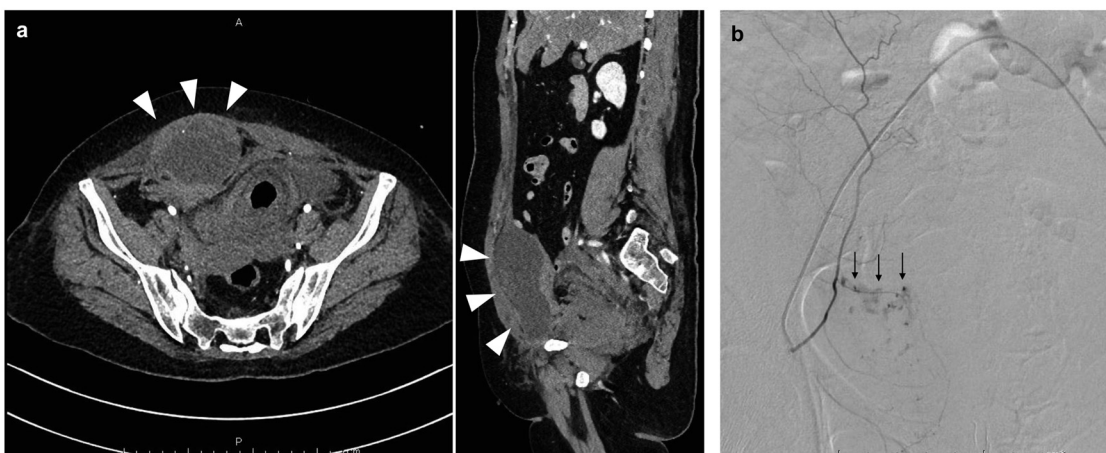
A: Enhanced abdominal computed tomography reveals a mass in the right abdominal wall (white arrowhead). (B) Selective angiography before embolization reveals bleeding (black arrow) from the right inferior epigastric artery.
